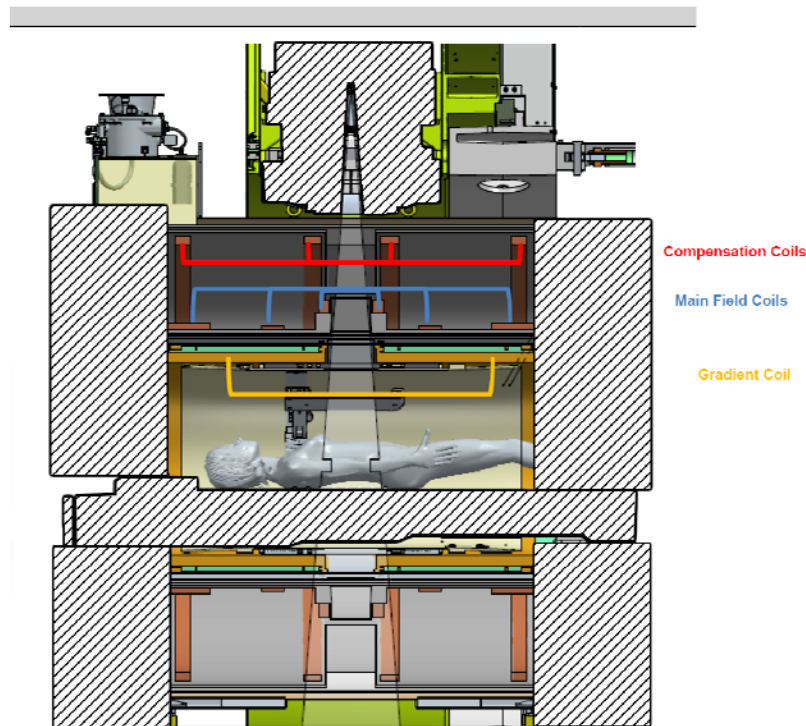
Compensation Coils, Main Field Coils and Gradient Coils in the MRI Component
